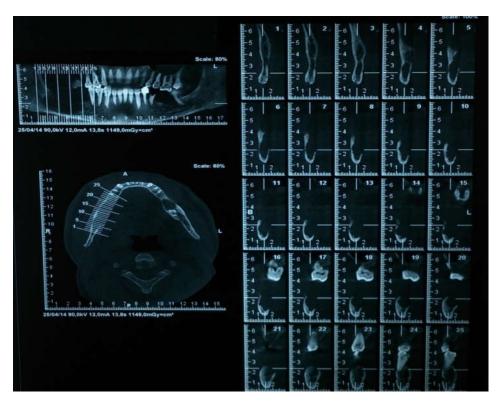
CBCT revealing expansive osteolytic lesion blowing the cortical in the buccal side and interrupting it in the lingual side
